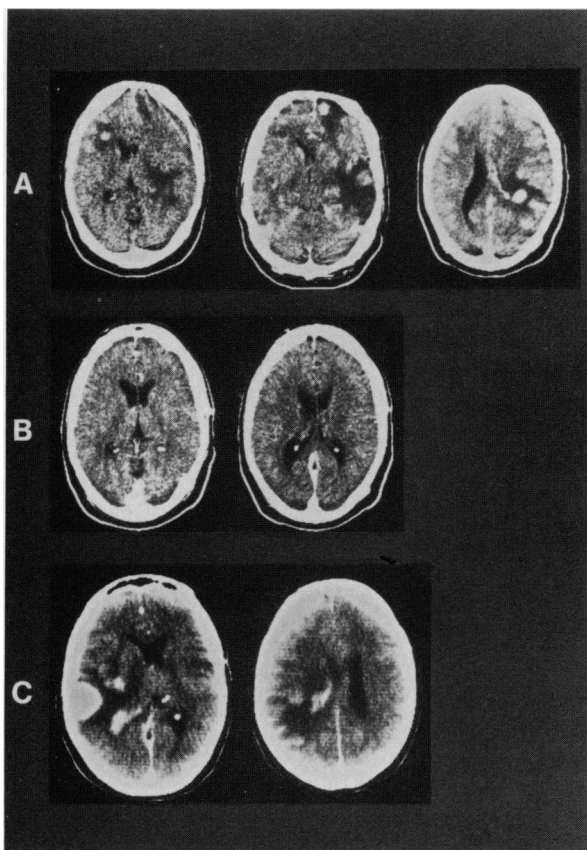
On computerized tomographic scan with contrast, multiple enhancing lesions surrounded by edema of the left frontal parietal and right frontal parietal temporal regions (A). Normal CT scan after treatment with steroids (B). Appearance of an enhancing mass lesion with surrounding edema in the left temporal area (C)
